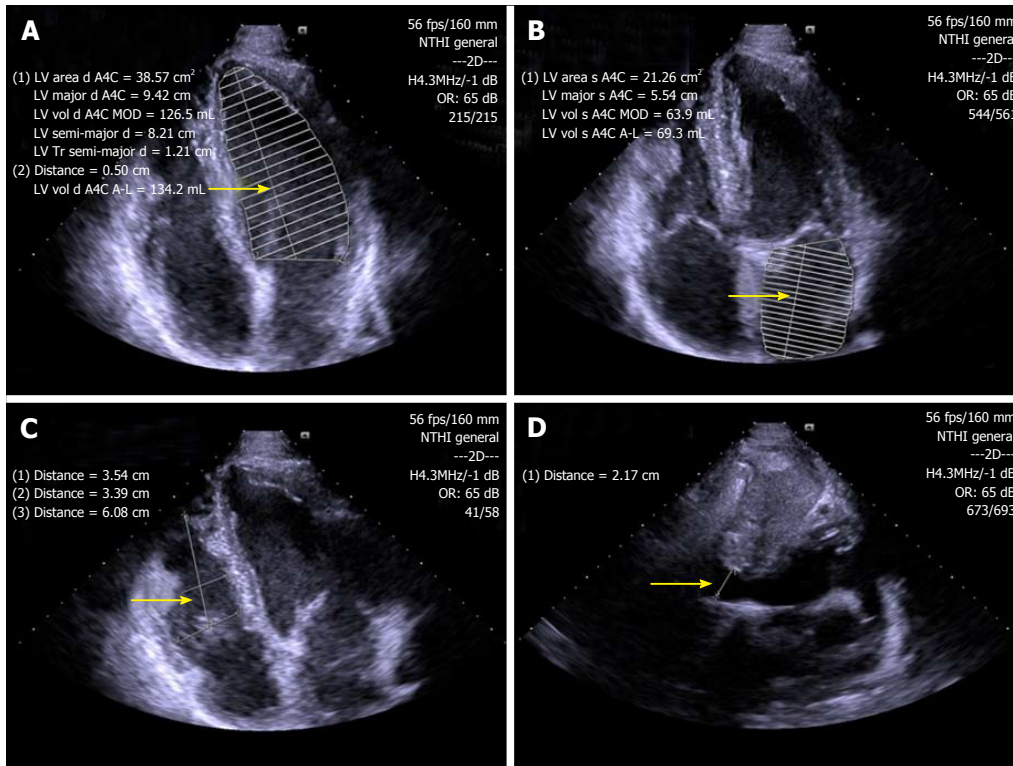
Standard B-mode echocardiography of endurance athlete showing enlargement of left ventricular (A), left atrial (B) and right ventricular (C) chambers, as well as inferior vena cava vein dilatation (D) (arrows). LV: Left ventricular.
